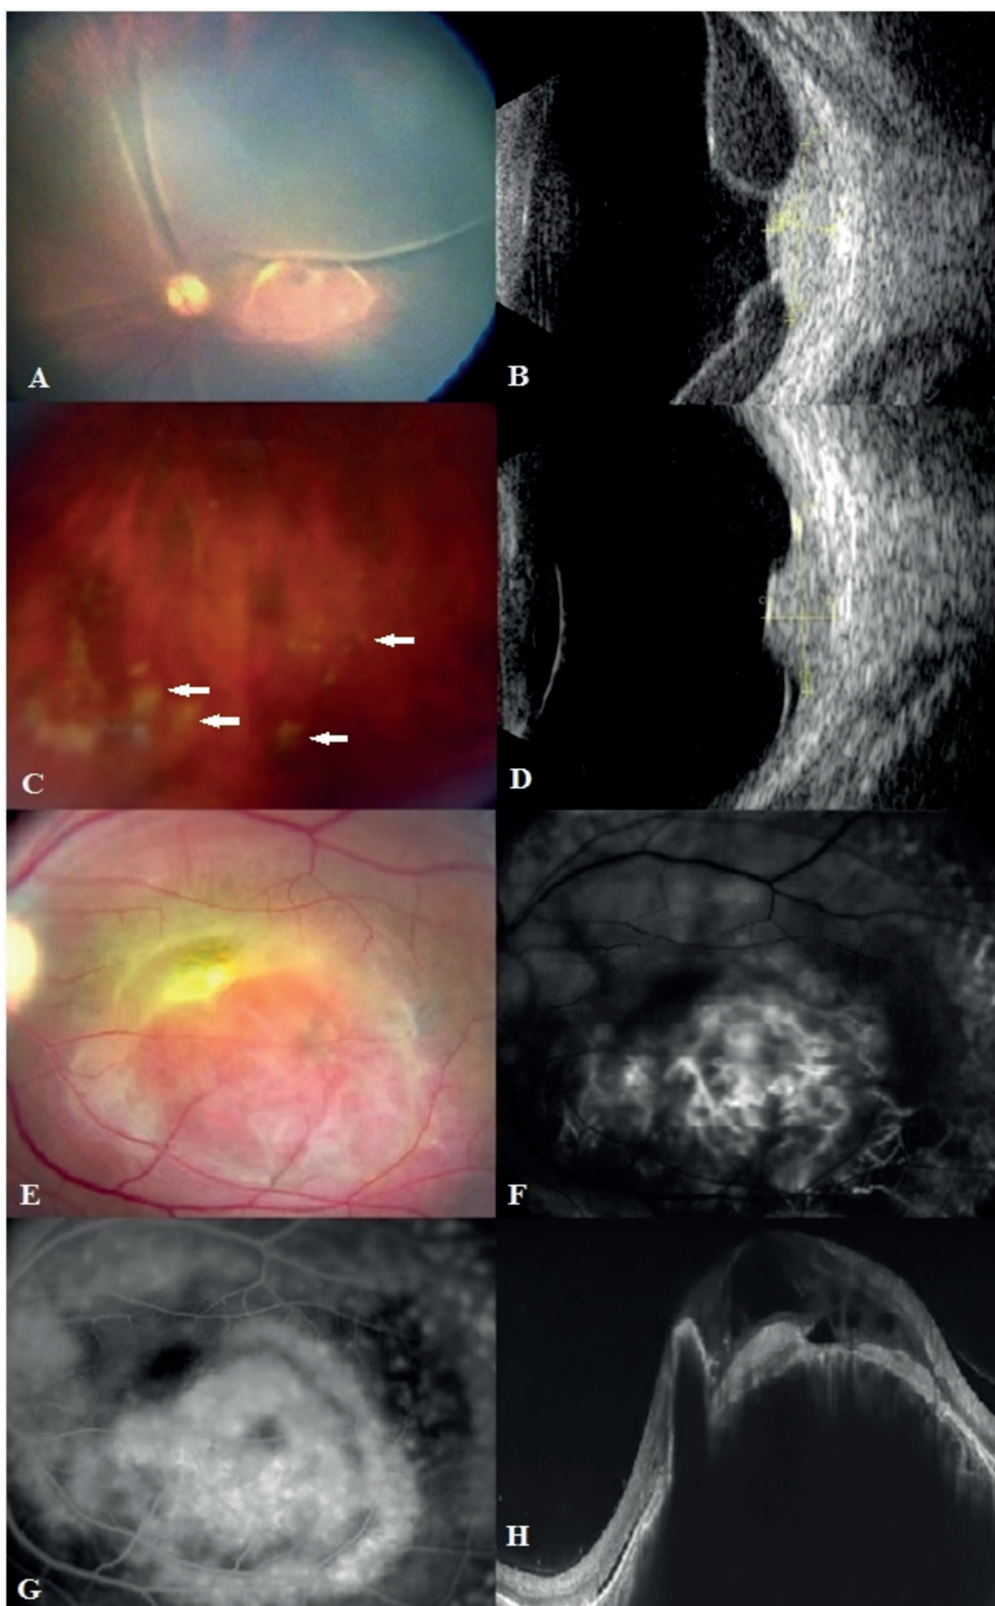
Multimodal imaging of patient with circumscribed choroidal hemangioma. Before treatment: RetCam fundus photo showed orange lesion located in macula and exudative retinal detachment (A). Ultrasonography revealed a solitary choroidal mass, surrounded by a retinal detachment (B). One week after subretinal injection of TA. Fundus photo showed white subretinal deposit of triamcinolone acetonide (white arrows) (C). Ultrasonography of the eye demonstrated solitary choroidal lesion and residual retinal detachment (D). Fundus photo showed orange lesion located in macula (E). Early phase fluorescein angiography revealed lacy hyperfluorescence of the lesion (F). Late phase fluorescein angiography demonstrated increased hyperfluorescence corresponding to the circumscribed choroidal hemangioma (G). Spectral domain optical coherence tomography showed a single choroidal lesion with the elevation of retinal pigment epithelium-Bruch's membrane complex, intraretinal and subretinal fluid (H)
